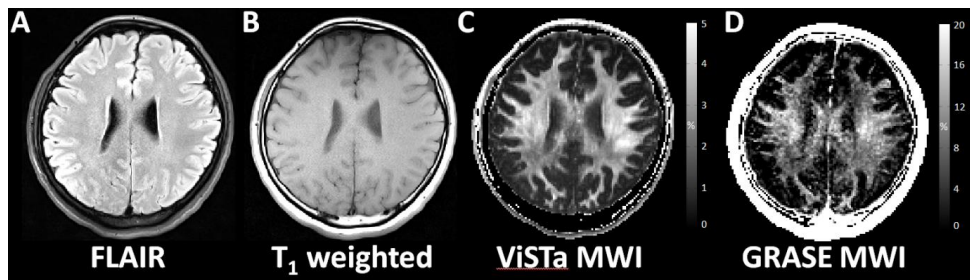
Representative FLAIR (A), T1 weighted (B), ViSta aMWF (C), and GRASE MWF (D) images from a 32-years-old healthy female.
